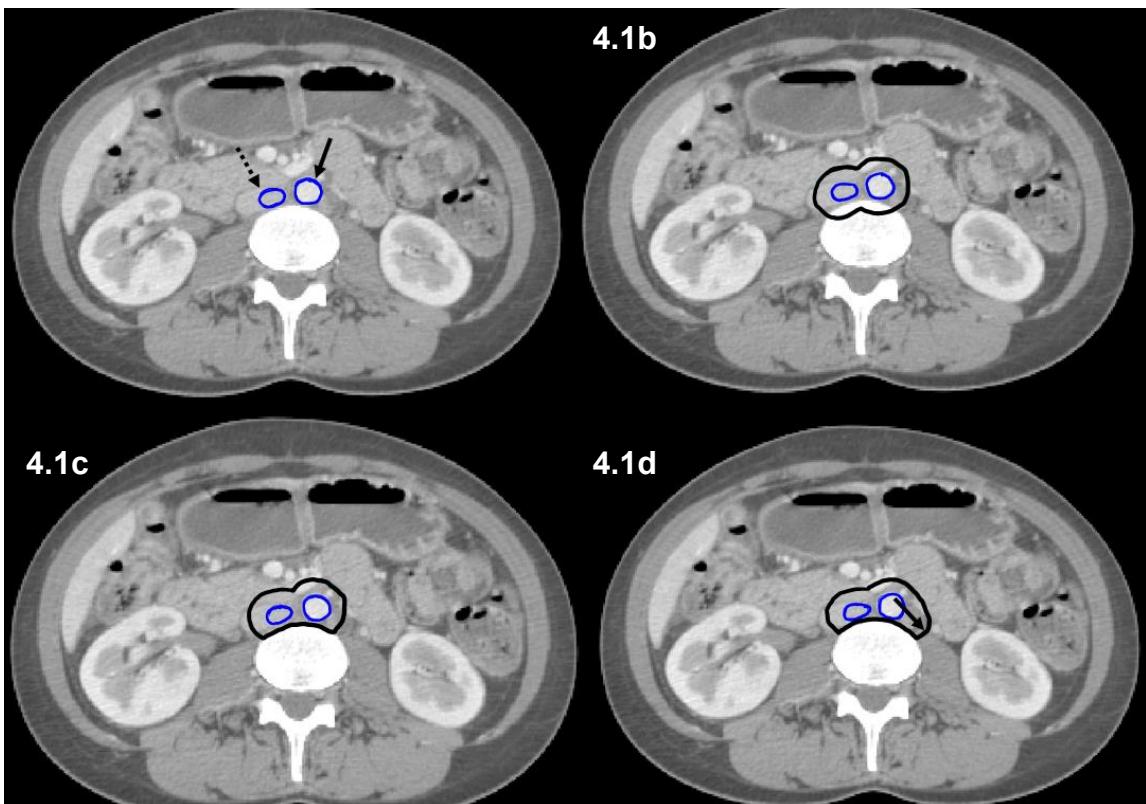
(a) Axial CT of vessels (blue: aorta solid arrow; IVC dashed arrow). (b) 7mm margin added (black). (c) edited off bone and muscle. (d) extended along vertebrae to psoas muscle (arrowed) to create CTV3
